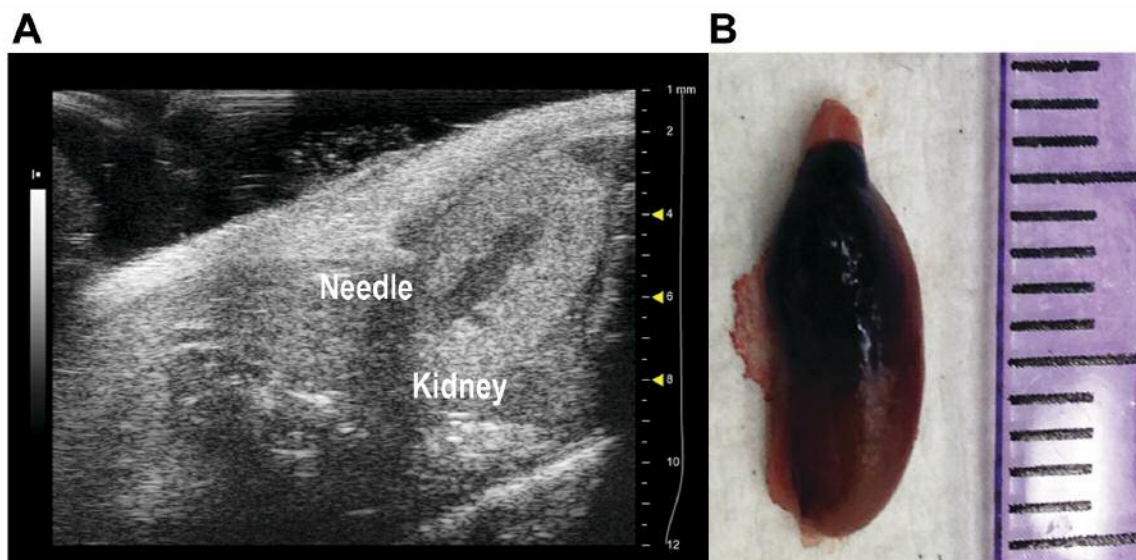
Renal subcapsular implantation of Ewing sarcoma (ES) cells. A: Single-cell suspension of ES cells were implanted beneath the renal capsule using ultrasound-guided needle injections. B: Renal subcapsular injection was first demonstrated using methylene blue dye and matrigel. Representative ex vivo image of left kidney post-injection is shown.
